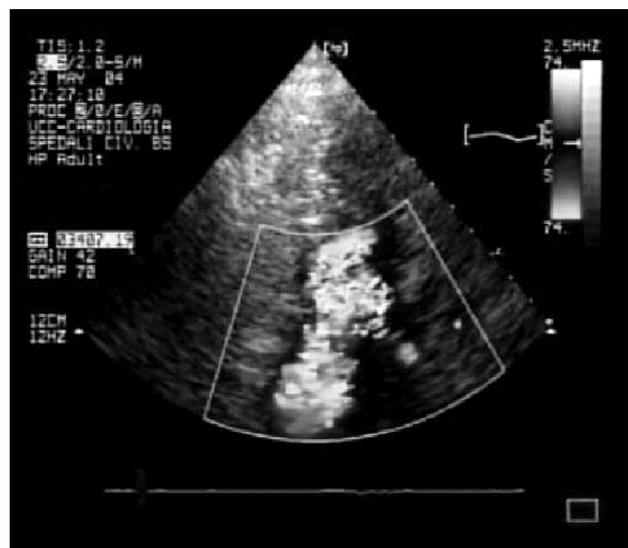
Echocardiographic examination showing severe mitral regurgitation with a high velocity jet directed toward the right pulmonary vein.
